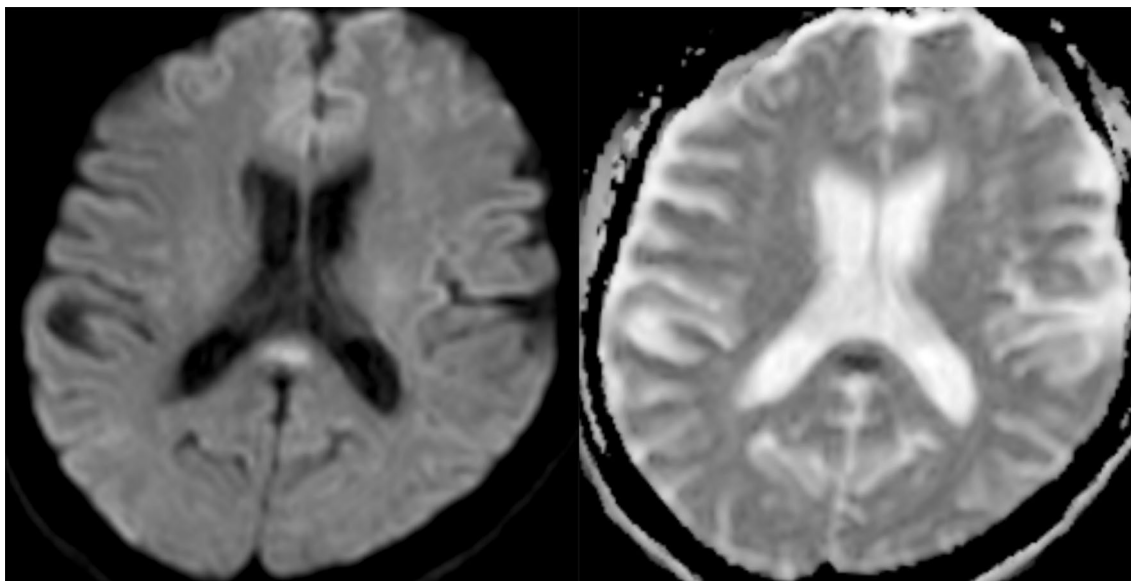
Axial brain MRI images demonstrate increased diffusion weighted signal in the splenium of the corpus callosum (left), confirmed as low signal on the ADC map (right)
